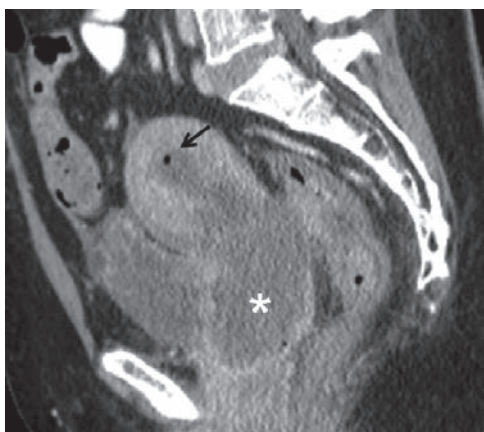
A 46-year-old woman with cervical cancer presented with pelvic pain and fever. Sagittal contrast enhanced CT image demonstrates a large cervical mass (*). There is obstruction of the endometrial cavity which is mildly distended and contains fluid and air (arrow), compatible with infection/pyometra.
